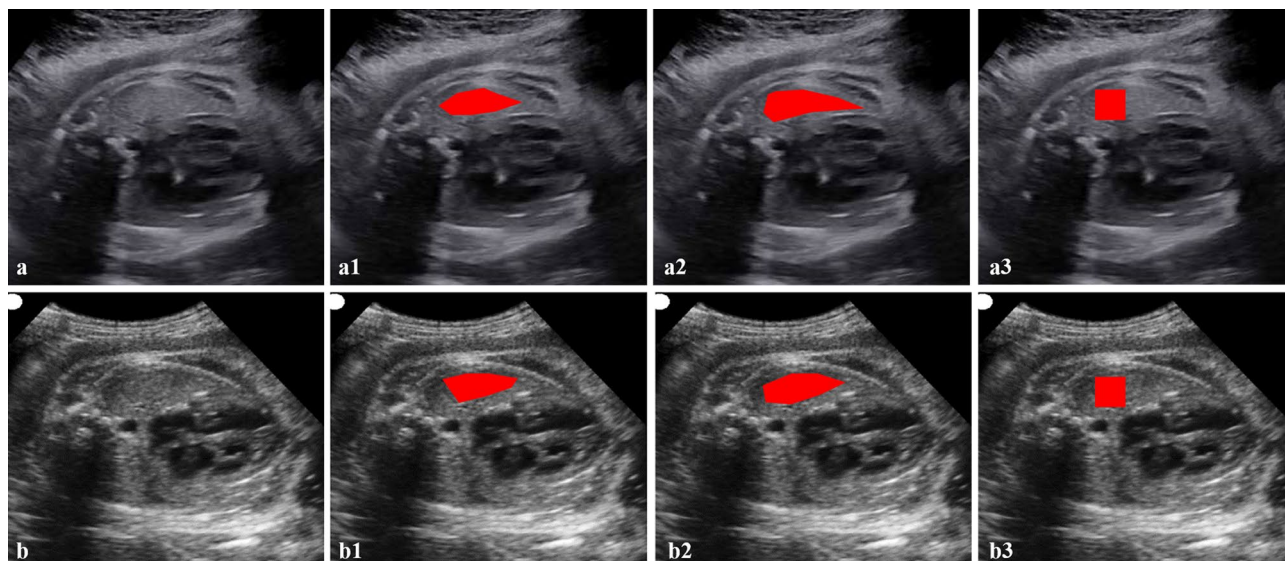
Fetal human lung ultrasound images with defined regions of interest. (a,a1,a2,a3) Are images of training set. (b,b1,b2,b3) Are images of testing set. (a1,b1) Manual delineation (radiologist A) of each lung. (a2,b2) Manual delineation (radiologist B) of each lung. (a3,b3) Square delineation (40 × 40 pixels) of each lung. (a,a1,a2,a3) Image of left lung at 36⁺¹ weeks in woman with pre-eclampsia (PE). Cesarean delivery occurred 2 days after ultrasound examination, and baby was diagnosed with transient tachypnea of the newborn. The risk probability derived from the model is 0.829 (>0.5). (b,b1,b2,b3) Image of left lung at 34⁺⁰ weeks in woman with gestational diabetes mellitus (GDM). Cesarean delivery occurred immediately after ultrasound examination, and baby was diagnosed with respiratory distress syndrome. The risk probability derived from the model is 0.843 (>0.5).
